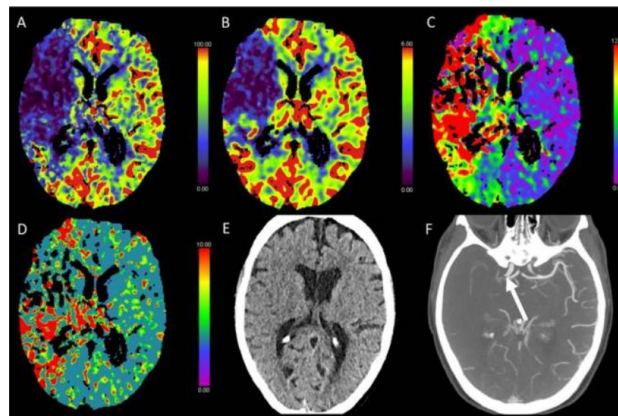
Maps produced from brain CT perfusion show: (A) CBF in mL/100 g/min, (B) CBV in mL/100 g, (C) Tmax in seconds, and (D) MTT in seconds. (E) Regular CT scan (NCCT) and (F) CTA. This patient had a cardiac catheterization procedure done to close an atrial septal defect. NCCT displayed a minimal decrease in the differentiation between gray and white matter. Within the middle cerebral artery (MCA) territory on the right side, there was a decrease in CBF while Tmax and MTT were increased. CTA discovered a blockage in the distal internal carotid artery on the right side (Haggenmüller et al., 2023).
